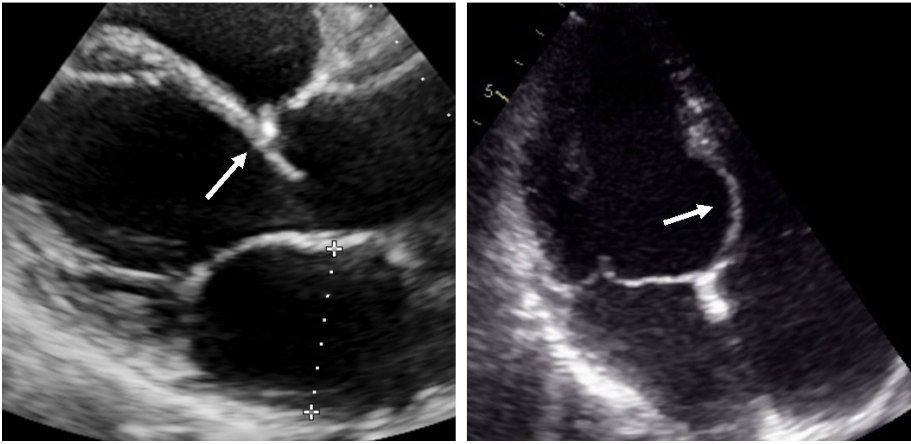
Thinning of the basal septum in cardiac sarcoidosis. Left panel: parasternal long-axis view showing abnormal thinning of the basal septum (white arrow). Right panel: Apical four-chamber view showing aneurysmatic thinning of the basal septum (white arrow).
